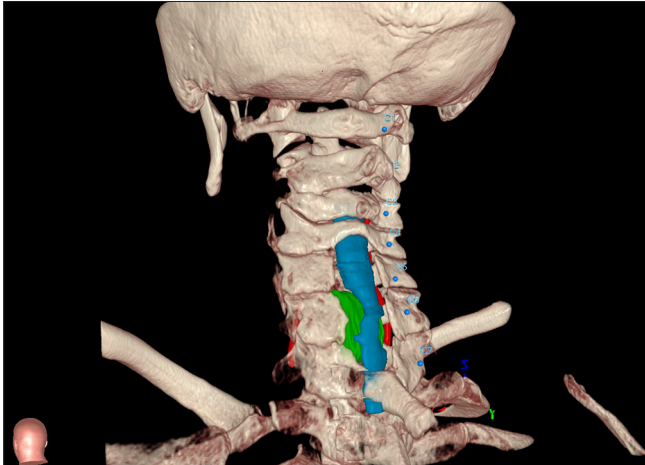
Preoperative 3D reconstruction from patient's computed tomography scans demonstrating bony defect (red arrow) from prior laminectomy.
